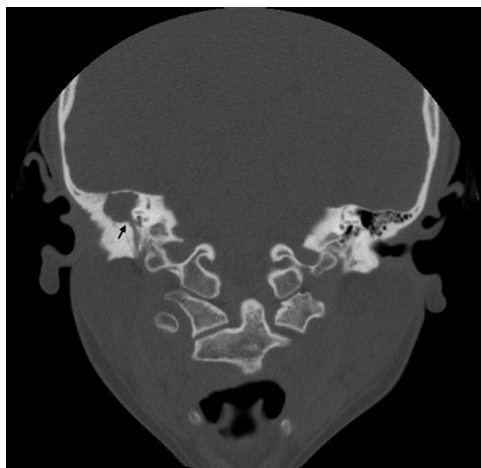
Computed tomography scan of the temporal bone (coronal view) showing bony dehiscence of tegmen mastoideum and the mastoid segment of facial nerve (arrow)
